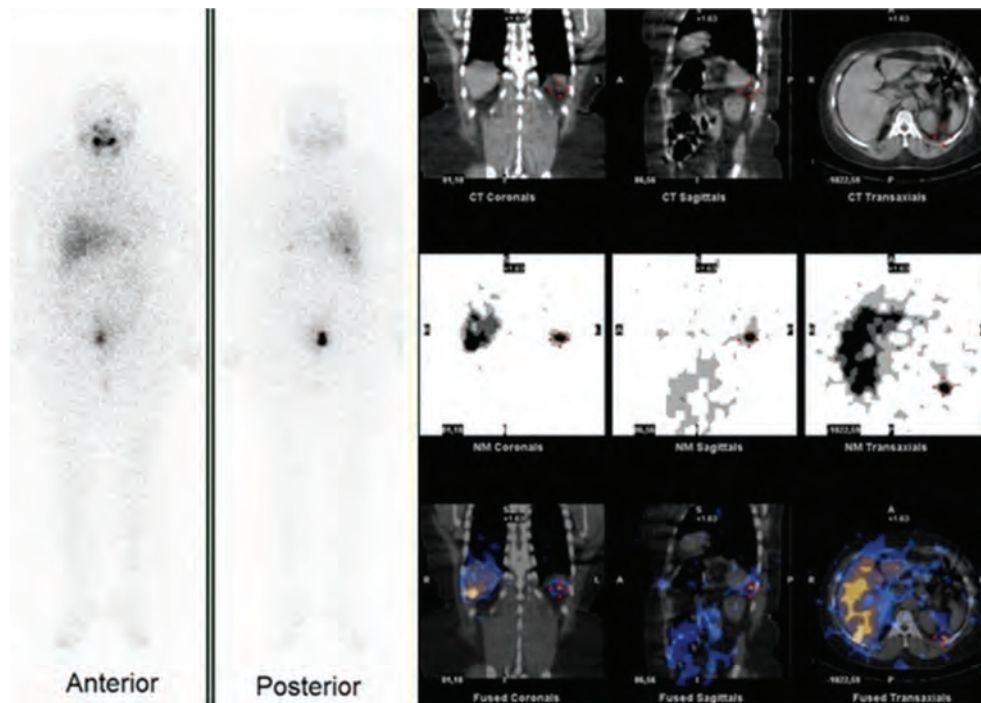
A 55-year-old female who underwent bilateral total thyroidectomy and received 100 mCi RAI ablation therapy due to the pathology result of multicentric papillary carcinoma, SPECT/CT imaging was performed due to the detection of suspicious foci on the right and left sides of the abdomen in the WBS on the 7th day of the treatment. In SPECT/CT images, one intense RAI involvement was observed in the 6th segment of the liver and adjacent to the ribs in the inferoposterior of the spleen. In planar imaging with SPECT/CT, the RAI involvements observed as suspicious in the abdomen were anatomically correlated and metastasis was reported
